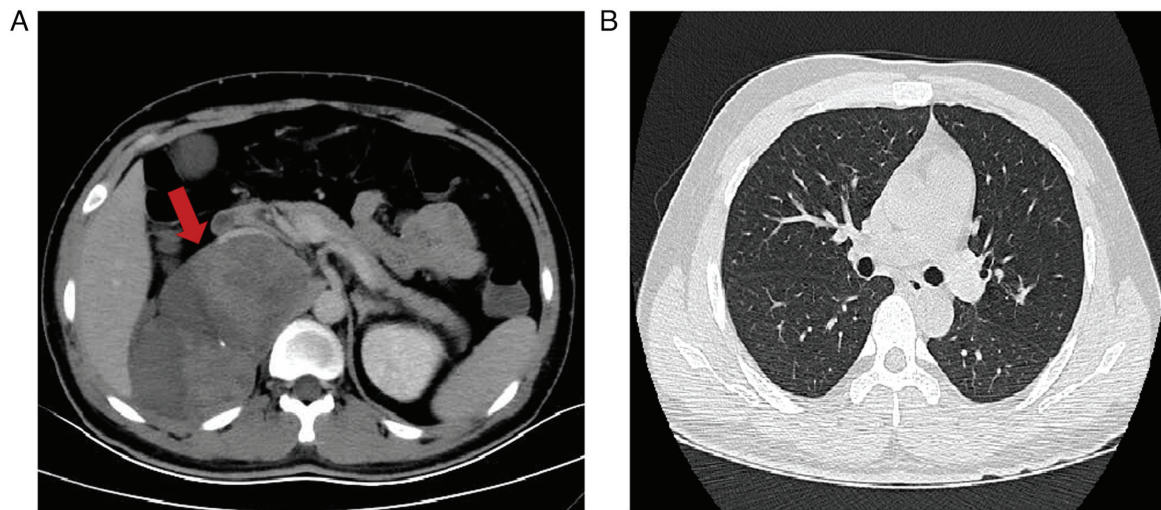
CT findings 5 months post-operation. (A) A significant increase in the size of nodules in the surgical area is observed, with certain nodules in retroperitoneum merging into masses (red arrow). (B) No metastatic lesions were observed on the chest CT.
